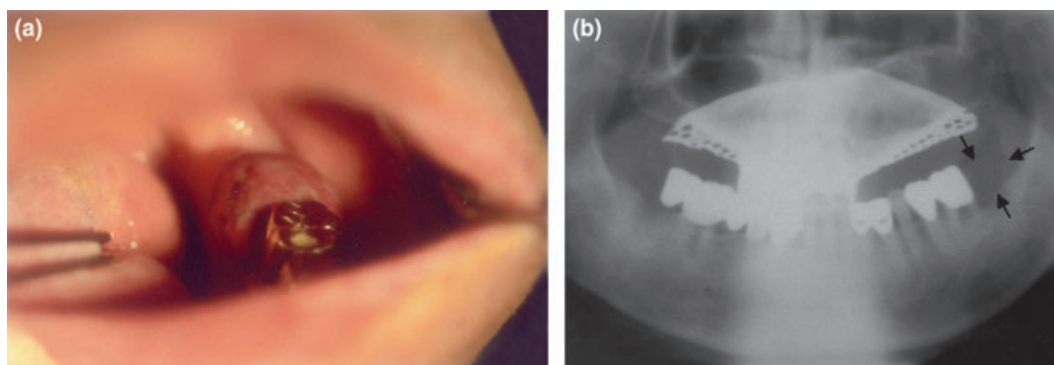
(a) A rapidly growing mass measuring about 2 cm in diameter is present in the left first lower molar area of the mandible. (b) A panoramic X-ray view reveals a relatively well-demarcated round osteolytic lesion.
